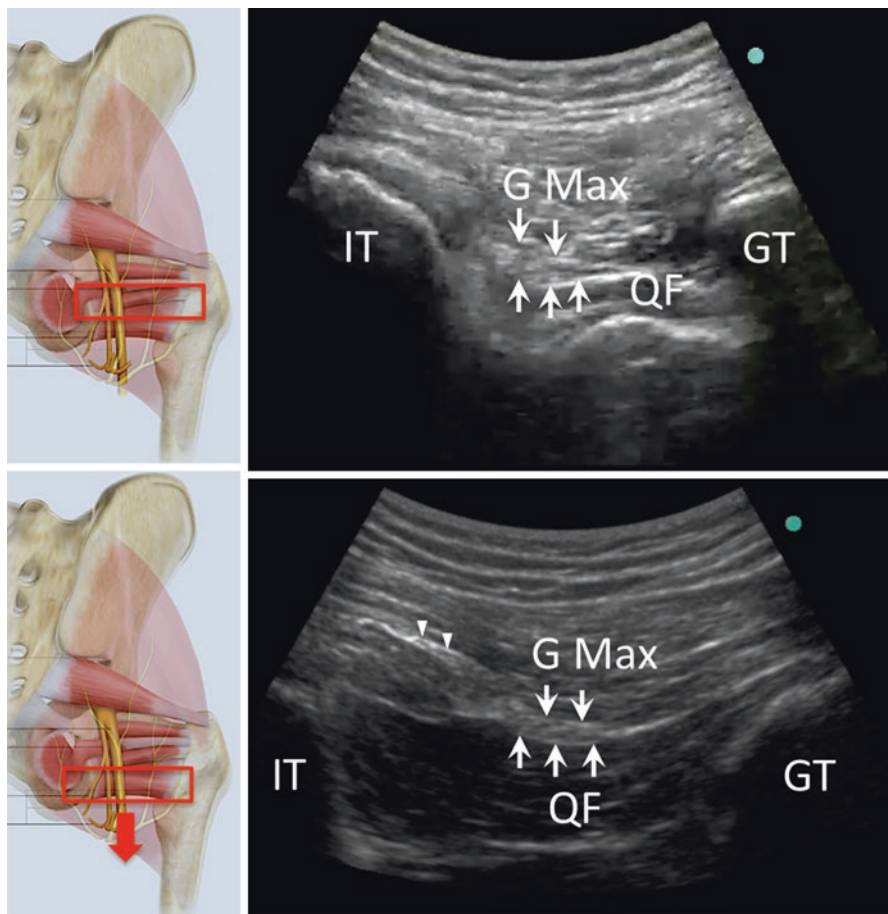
Position of ultrasound probe and the corresponding sonography for the inferior cluneal nerve. Arrow, sciatic nerve; arrow heads, inferior cluneal nerve; G Max, gluteus maximus; QF, quadratus femoris. (Reprinted with permission from Philip Peng Educational Series)
